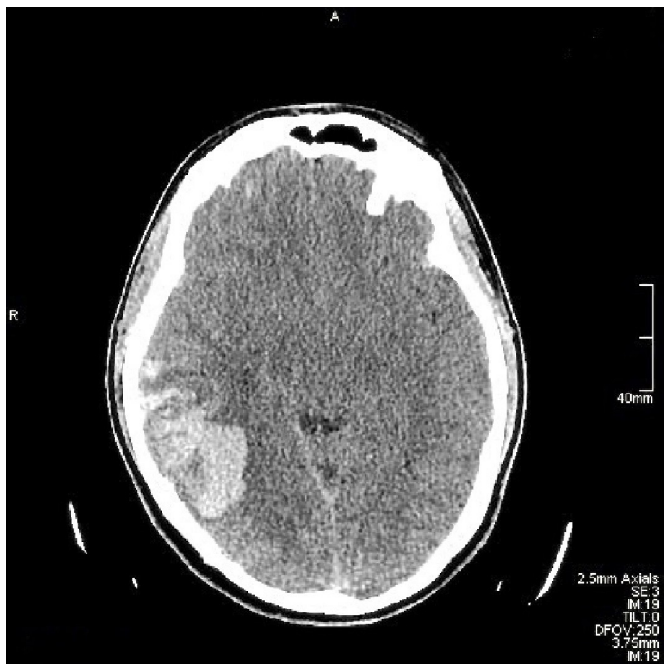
CT of the head showing a 5.3×3.2 cm acute parenchymal haemorrhage in the right parietal lobe with mild perifocal oedema.
